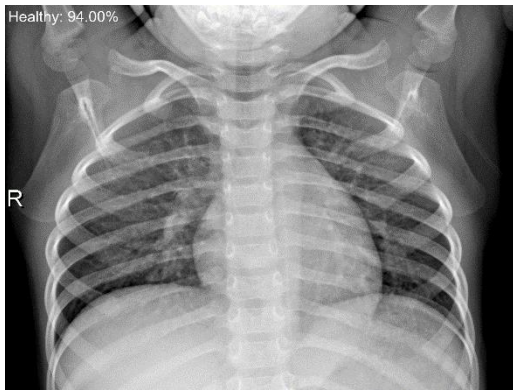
The output of the model for a chest x-ray image of a person known to be healthy.
